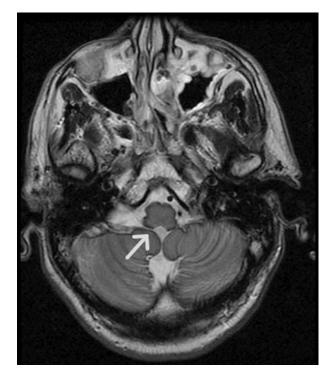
Axial, T2-weighted magnetic resonance image demonstrating a hypointense rim surrounding the cerebellum (arrow).
